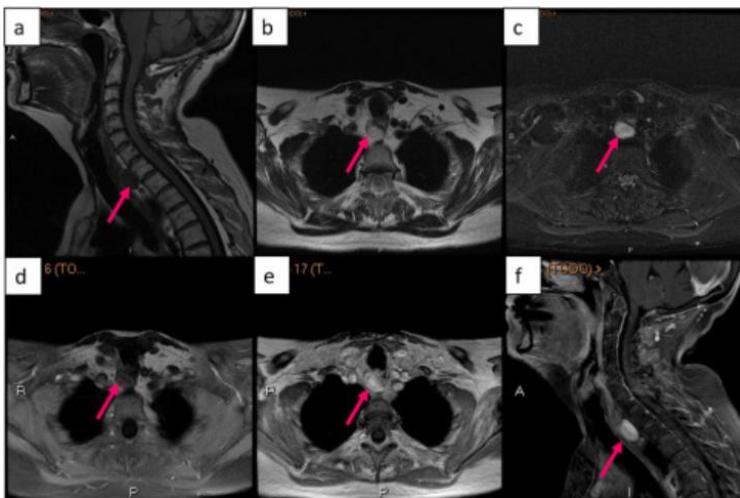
RETROTRACHEAL PARATHYROID ADENOMA DETECTED BY MRI. ADAPTED FROM (9).
